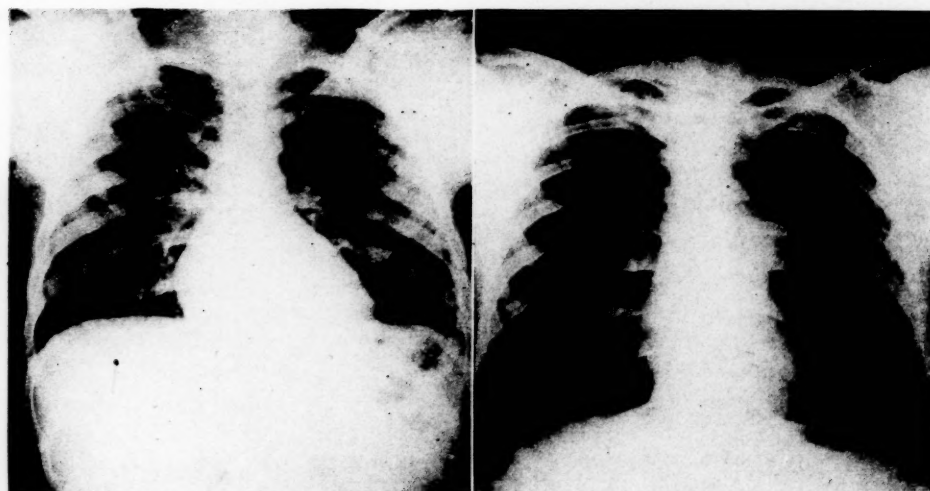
Roentgenogram of the patient's chest in Case III; note the absence of enlargement of the pulmonary artery.
